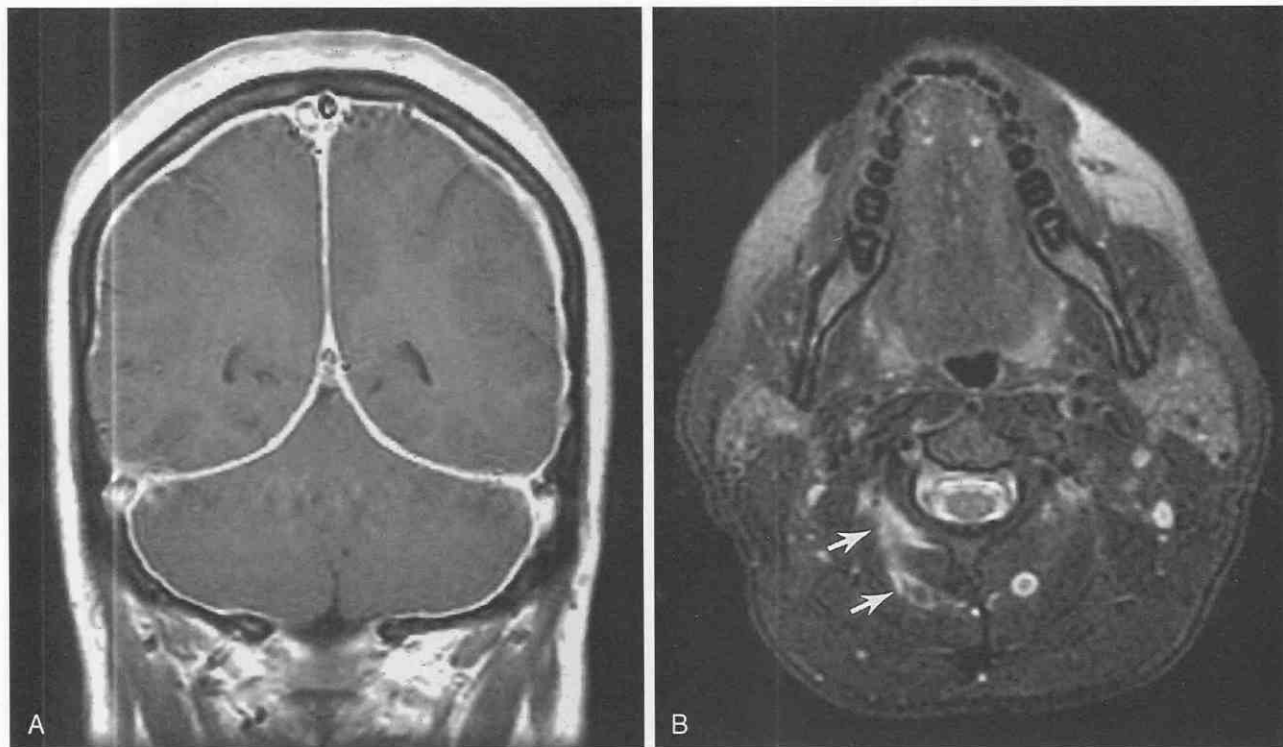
Intracranial hypotension. Coronal T1-weighted image demonstrates diffuse dura/arachnoid enhancement in this patient who presented with severe headaches and whose CSF pressure was low on lumbar puncture. The axial T2-weighted image shows fluid, presumed to be cerebrospinal fluid in the soft tissues of the upper neck (arrows). The patient recovered after surgery despite the fact that, although myelography revealed a leak, the exact site could not be found at operation.
